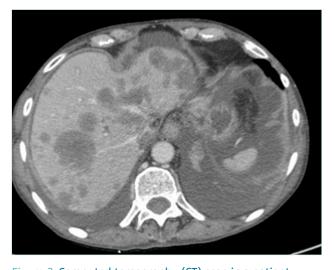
Computed tomography (CT) scan in a patient with metastatic liver and ascites with inferior vena cava occlusion.
